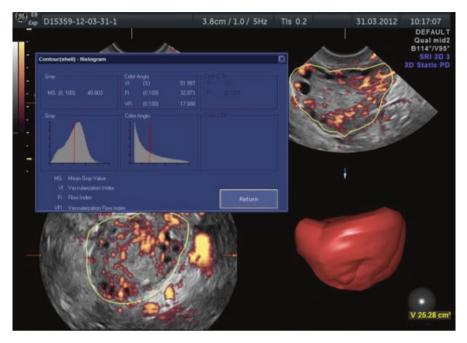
3D power Doppler of the polycystic ovary with volume histogram showing 3D power Doppler indices VI, FI and VFI of the ovary
